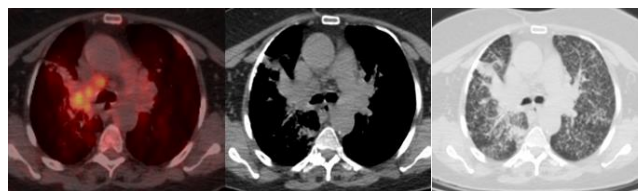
PET-CT Imaging of Case 2: Increased FDG uptake in a 35x25 mm soft tissue mass in the upper lobe and mediastinal lymph nodes
